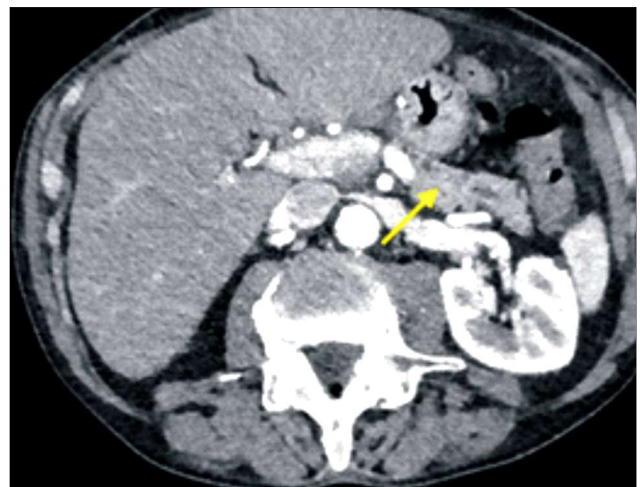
Computed Tomography (CT) showing pancreatic remnant without pathological findings (arrow)
